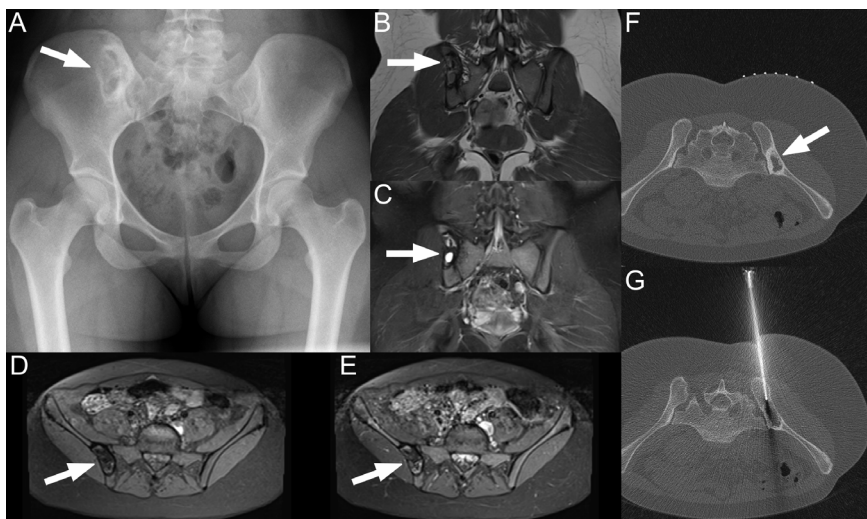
A 19-year-old girl without any relevant medical history presented with long lasting vague left-sided abdominal pain, for which a plain abdominal radiograph was ordered to assess for constipation. Although the radiograph did not show any signs of intestinal pathology, it revealed a lytic lesion with sclerotic margins in the right iliac wing (A, arrow). The lesion was asymptomatic. MRI with coronal T1-weighted (B), coronal fat-suppressed T2-weighted (C), axial fat-suppressed T1-weighted (D), and axial gadolinium-enhanced fat-suppressed T1-weighted (E) sequences showed the lesion to be predominantly T1 hypointense, heterogeneously T2 hyperintense, and with minimal enhancement after gadolinium administration (arrows). Axial 2.0-mm pre-biopsy planning CT showed a lytic 40-mm lesion in the right iliac wing (F, arrow), with a sharp transition zone and a sclerotic rim, but no periosteal reaction, cortical destruction, or associated extraosseous soft tissue mass. Axial CT shows the tract of the biopsy needle just before tissue sampling was done (G). The acquired 12-mm tissue sample yielded insufficient material for a specific diagnosis to be made or to suggest a malignancy. A second CT-guided biopsy was performed three weeks later, which revealed osteonecrosis without any other lesional tissue.
